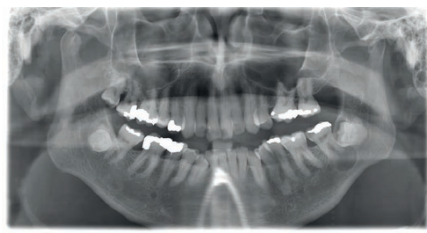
Orthopantomograph showing decayed 37 with large radiolucency around roots and impacted 38
